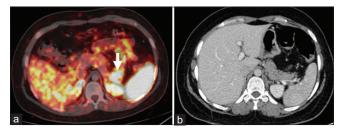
(a) Pancreatic tail nonfunctional - neuroendocrine tumor (arrow) identified in ⁶⁸Ga-DOTA-Nal3-octreotide positron emission tomography/ computed tomography (b) but missed on contrast-enhanced computed tomography
